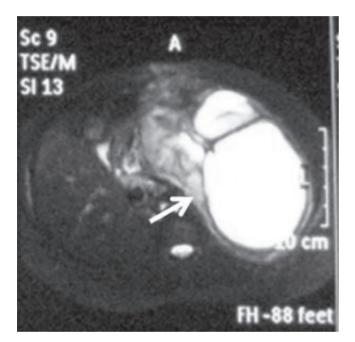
MRI Axial T2- weighted image of cystic lesion on the left adrenal.
